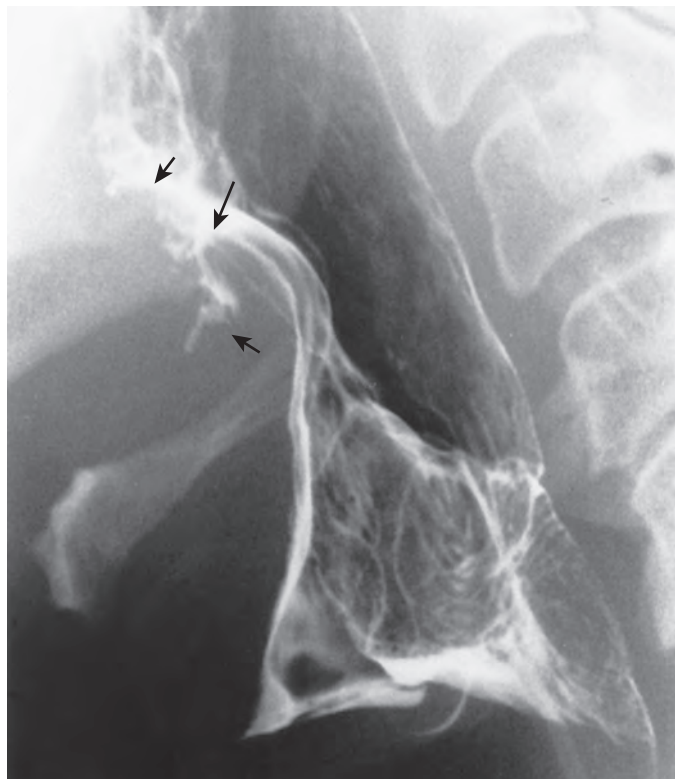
Adenocarcinoma of the minor salivary glands. The epiglottic tip (*long arrow*) is apposed to the base of the tongue, and its vallecular surface is ulcerated. The valleculae are obliterated and filled by a lobulated tumor (*short arrows*) arising from the tongue base. This adenocarcinoma is radiographically indistinguishable from a typical squamous cell carcinoma of the base of the tongue. The tumor presumably arose in minor salivary gland tissue.
